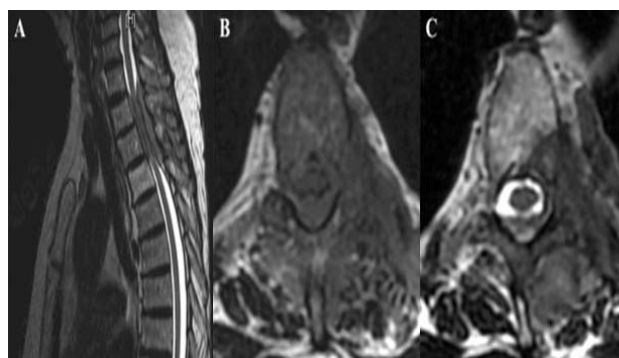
Extradural tumor . Sagittal T2-weighted MRI showing the dorsal epidural lesion with cord compression. B) Axial T2-weighted MRI showing circumferential epidural compression of the spinal cord by the tumor mass with, C) tumor extension through the intervertebral foramen with lateral extension into the paraspinal tissues
